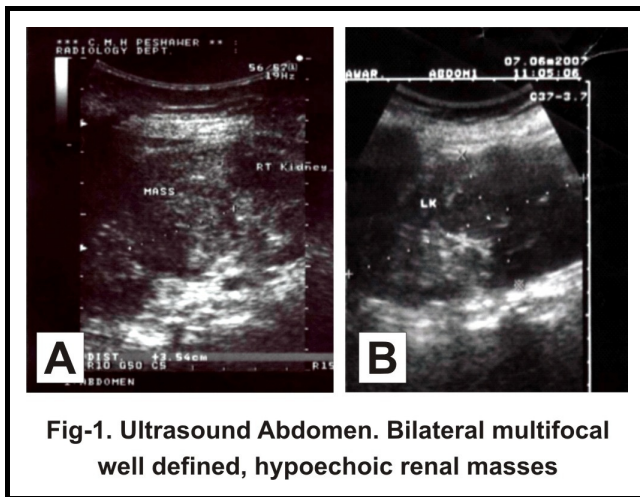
Ultrasound Abdomen. Bilateral multifocal well defined, hypoechoic renal masses
